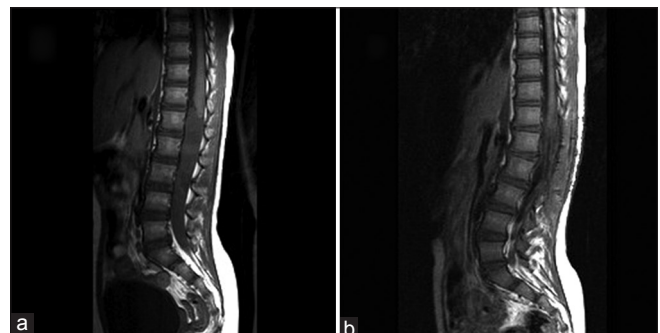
(a) Sagittal T1-weighted Gd-enhanced magnetic resonance images of myxopapillary ependymoma obtained preoperatively; (b) 48 h after gross total removal
